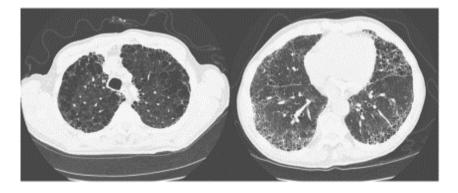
HRCT thorax of emphysema in upper lobe and pulmonary fibrosis in lower lobe (11)
